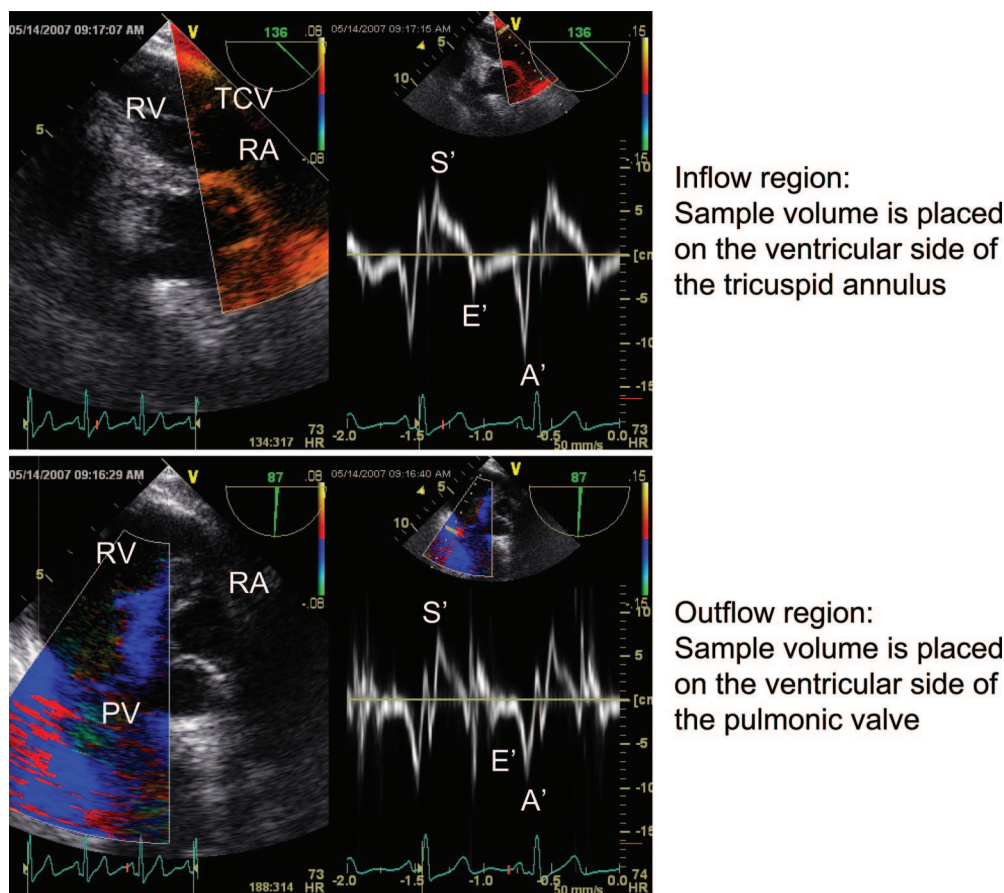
Doppler tissue imaging of the right ventricle (RV). The RV inflow (top) and outflow (bottom) regions are examined with color (left) and pulsed wave (right) Doppler tissue imaging, in the deep transgastric RV view. PV = pulmonic valve; RA = right atrium; TCV = tricuspid valve.
